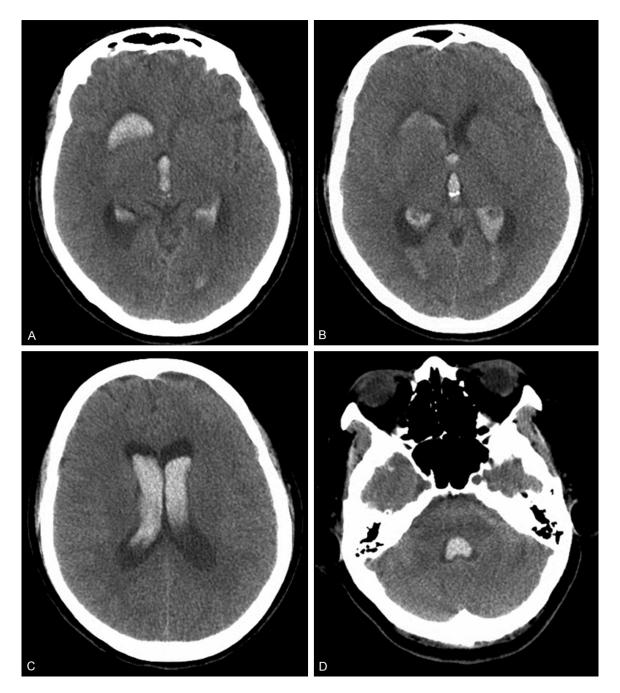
Head CT images. A, B: A caudate head hemorrhage extending into the frontal horn of the lateral ventricle and entering the third ventricle through the interventricular foramen. C: Blood filling the bilateral lateral ventricles. D: Bleeding into the fourth ventricle.
